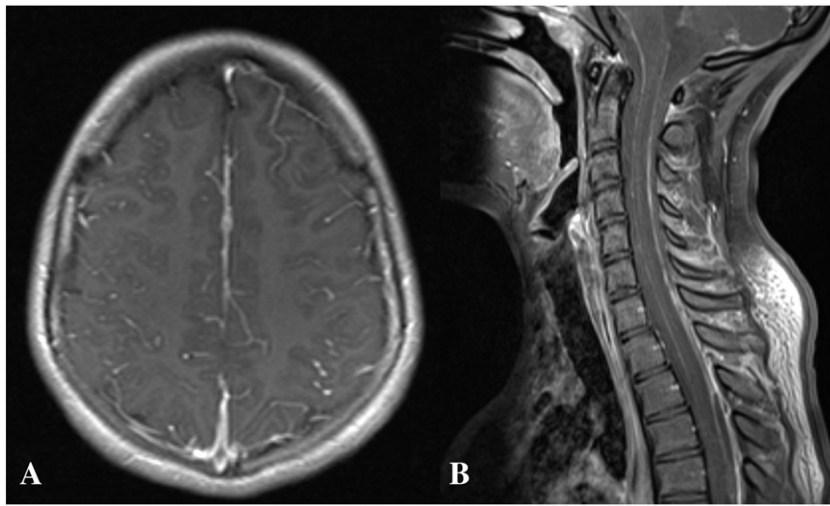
MRI of brain and spine. (A) Axial postcontrast T1 imaging showing leptomenigeal enhancement of the bilateral parietal regions. (B) Sagittal postcontrast imaging showing mild enhancement at multiple levels throughout the cervical spine.
